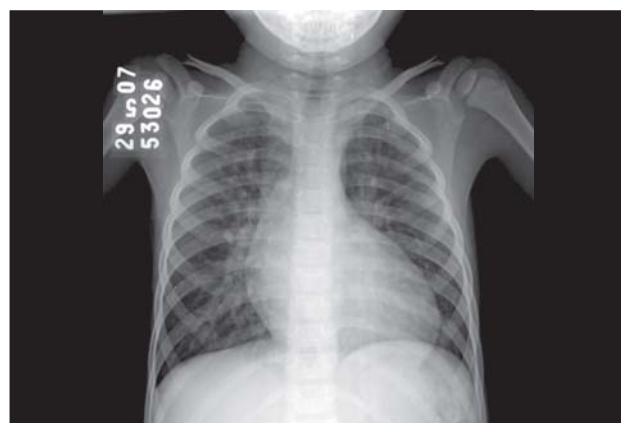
A typical PA radiograph of thorax of patients undergone transposition of the great arteries
